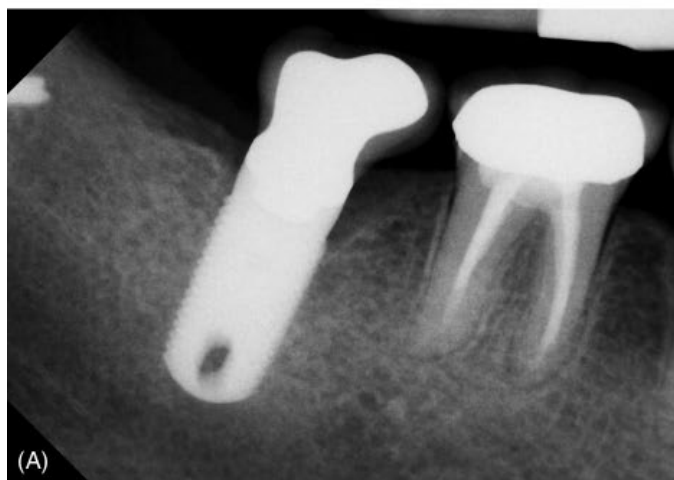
(A, B) Crestal and circumferential bone loss as seen on a radiograph.
